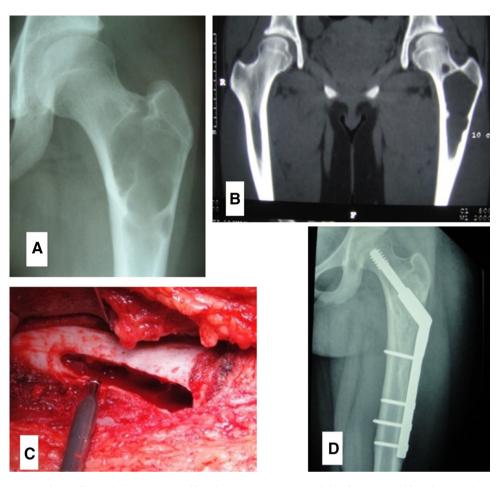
D (A) A preoperative radiograph shows an Enneking Stage 2 lesion of the left proximal femur. (B) The CT image shows the same Enneking Stage 2 lesion of the left proximal femur. (C) Thorough
